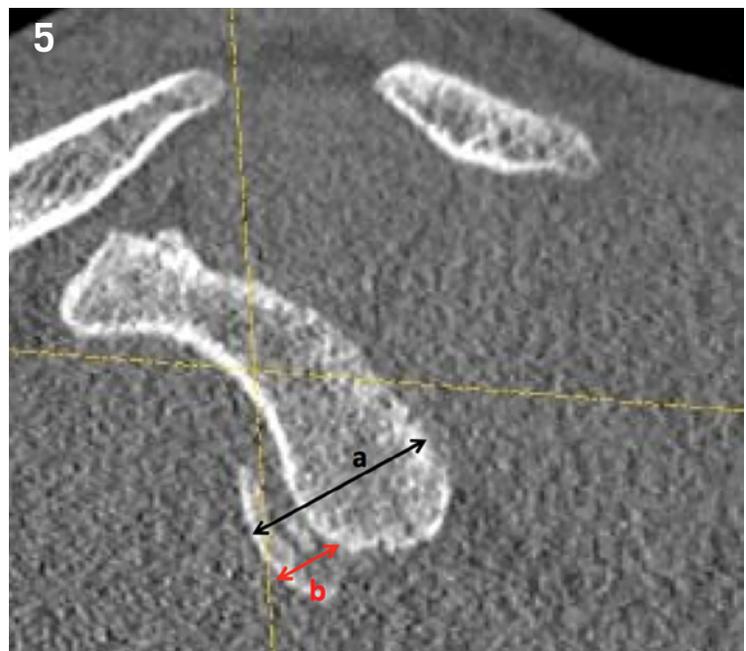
Sagittal CT image demonstrating Bankart lesion (b/a ratio is less than 0.20 to 0.25) therefore, bony Bankart repair (e.g. Latarjet procedure) may not be necessary. CT=computed tomography.
